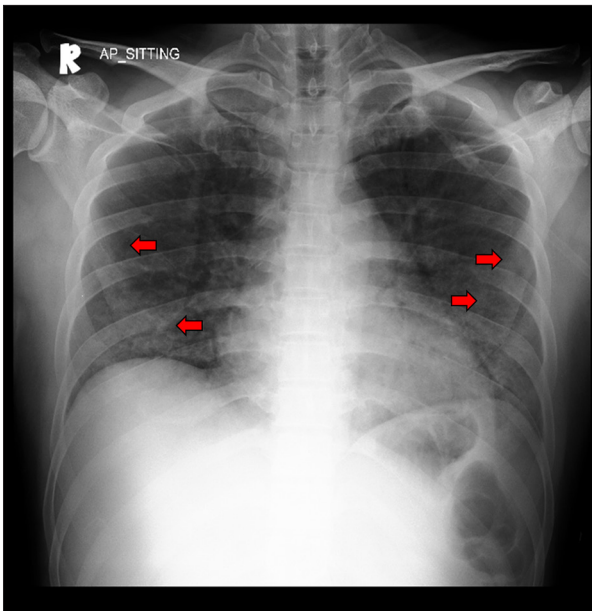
Chest X-Ray on July 13, 2020, showed ground-glass opacity areas with reticular changes in a perihilar distribution (red arrows).
